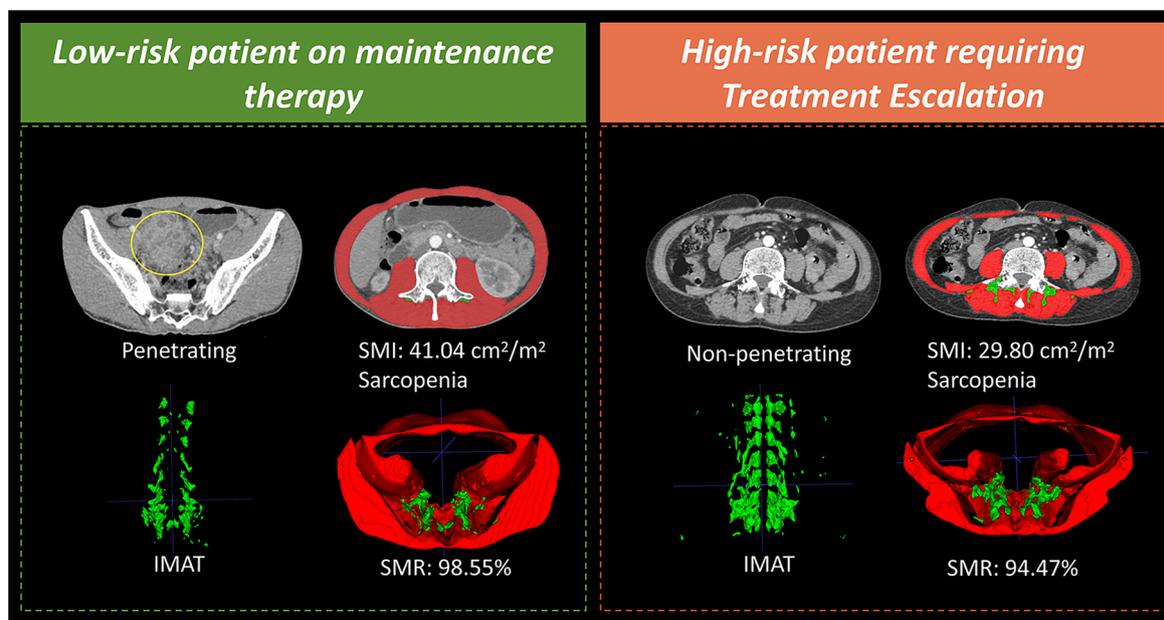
Comparison of skeletal muscle and IMAT measurements in low-risk and high-risk of skeletal muscle adiposity. Case 1: a 35-year-old male with baseline CTE score = 3, SES-CD score = 9, SMR = 98.55% (low risk), penetrating lesions, and sarcopenia. The patient maintained biologics therapy and demonstrated endoscopic remission (SES-CD = 1) after 15 months of follow-up. Case 2: a 53-year-old female with baseline CTE score = 3, SES-CD score = 6, SMR = 94.47% (high risk), and sarcopenia. The patient underwent surgery for a newly developed inter-intestinal fistula at the 8th month of follow-up. CTE, computed tomography enterography; SMR, skeletal muscle ratio; SES-CD, simple endoscopic score for crohn's disease.
